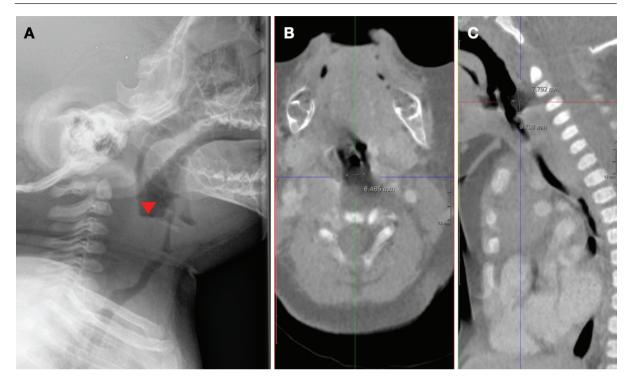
A) Lateral X-ray of the neck showing a retrocricoid mass. B and C) Computed tomography of the neck (axial and sagittal sections). Hypodense postcricoid formation
